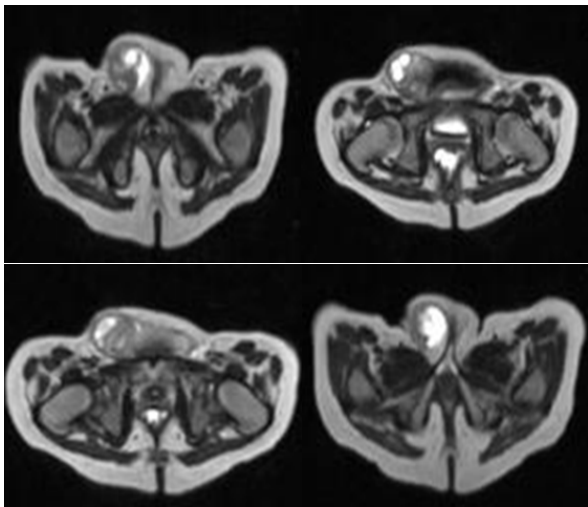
Axial T2 weighted MR images showing uterus and ovaries herniating into the right inguino-labial region.
